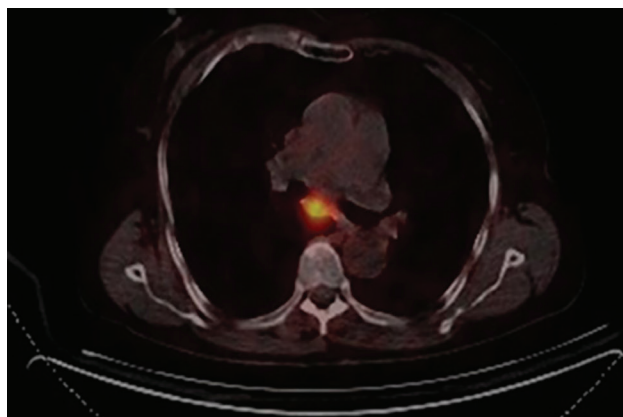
Dotatoc PET-CT showing avidity in mediastinal lymph nodes (station 7; standard uptake value 8.8).
